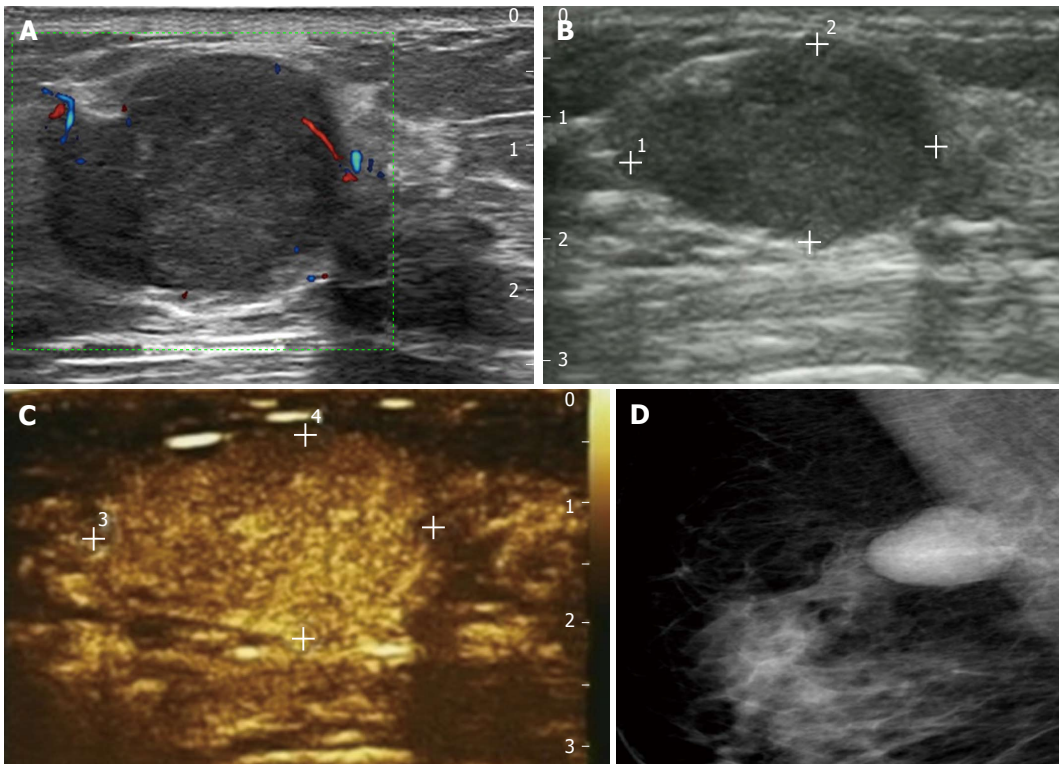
Enhancement patterns of triple-negative invasive ductal carcinoma. A: Color Doppler flow imaging with hypo-vascular; B and C: Homogeneous hyper-enhancement with rapid wash-in, irregular shape, clear margin and equal size, without perfusion defect, penetrating vessel and crab claw-like pattern; D: Mammography shows an adenoma or benign phyllodes tumor-like appearance with sharp clear margin and regular shape.
